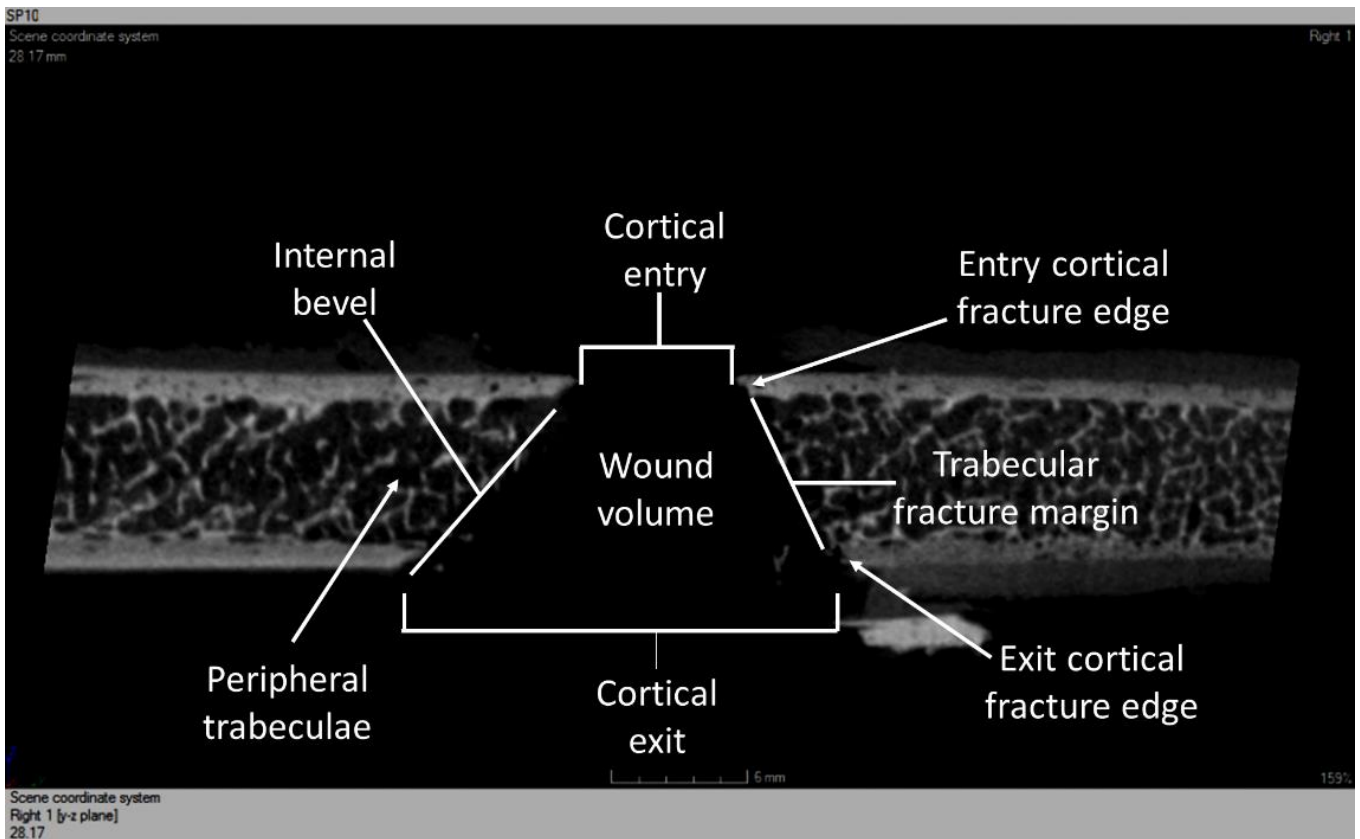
μ -CT image, y-z section showing cross-sectional anatomy of a perforating gunshot wound through a sandwich bone, incident velocity 335.55 m/s (σ 1.05); see text for explanation. Projectile passed from above downwards.
